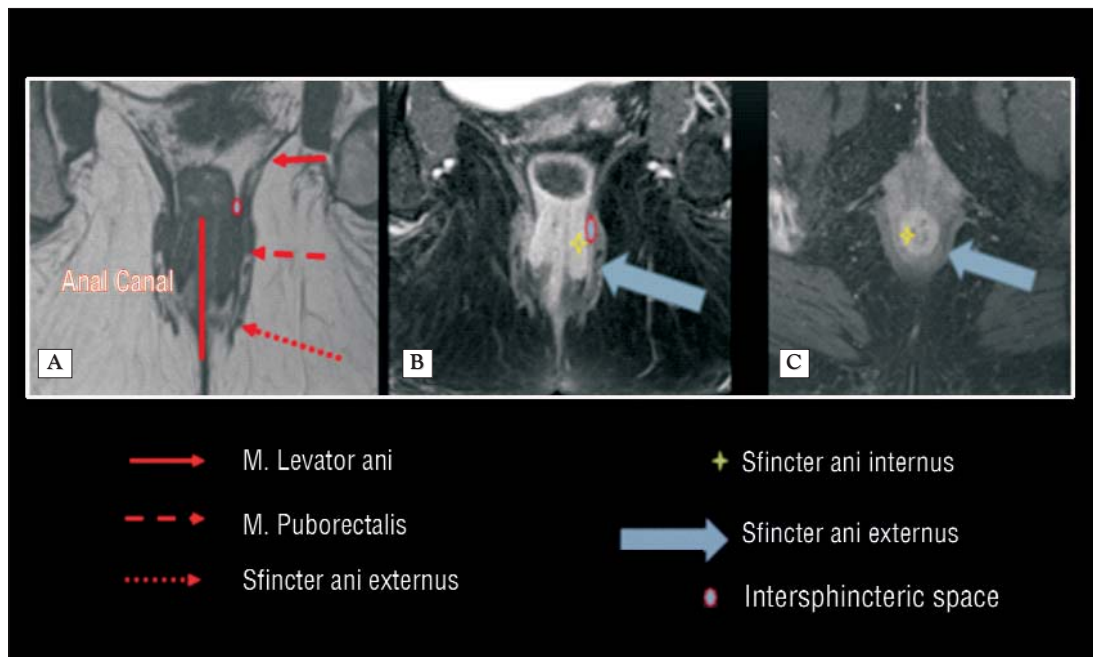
The anatomy of the anal canal. (A) the coronal T1-weighted MRI presents the external anal sphincter composed by the levator ani muscle, the puborectalis muscle and the external anal sphincter. (B) the coronal T1-weighted image with fat suppression (FS) after an intravenous contrast media injection: the internal anal sphincter (yellow star) continuing the muscularis propria layer of the rectum. The intersphincterian fat (red circle) the external anal sphincter (blue arrow). The internal anal sphincter (the yellow star) is better visualized after the administration of contrast medium. (C) Axial T1-weighted fat suppression after an intravenous injection with contrast medium. We can observe the internal anal sphincter (yellow star) and the external anal sphincter (blue star).*
